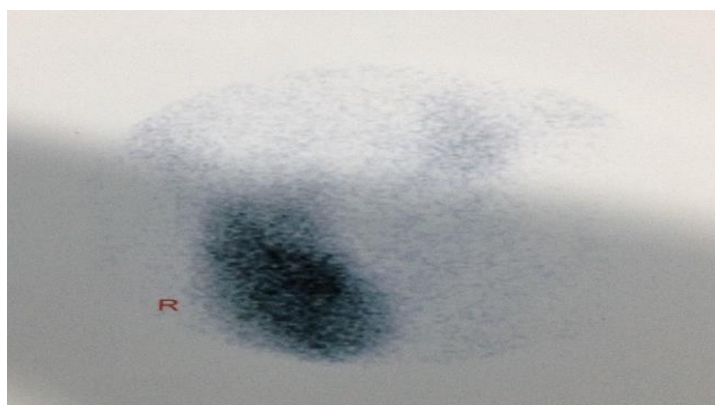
Tc-99m pertechnetate scintigraphy showing the right thyroid lobe and the isthmus. The left lobe was not seen.
